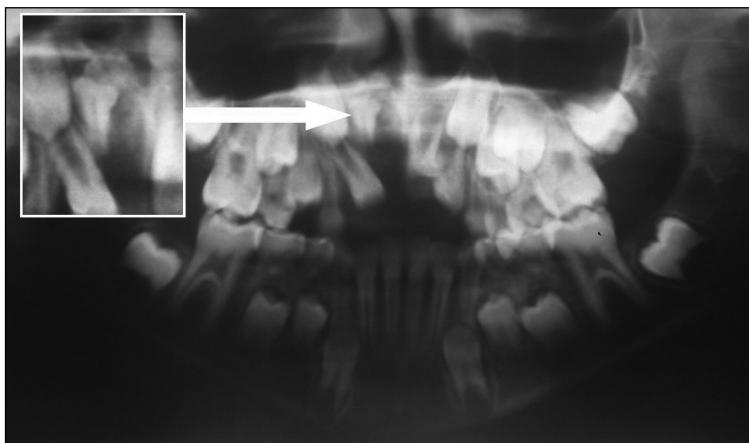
Panoramic radiograph of the 10-year-old patient showing inverted supernumerary teeth associated with an odontoma. Note the radiolucency around the supernumerary teeth.
